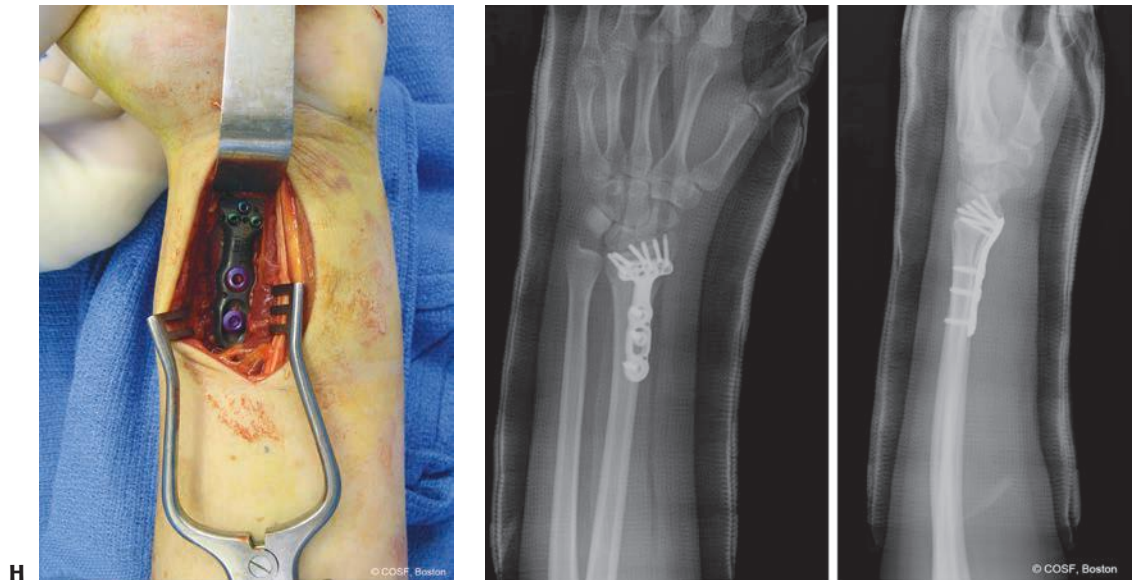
(continued) H: Plate fixation of fracture anatomically. I: Radiographs of ORIF with volar plating system.
